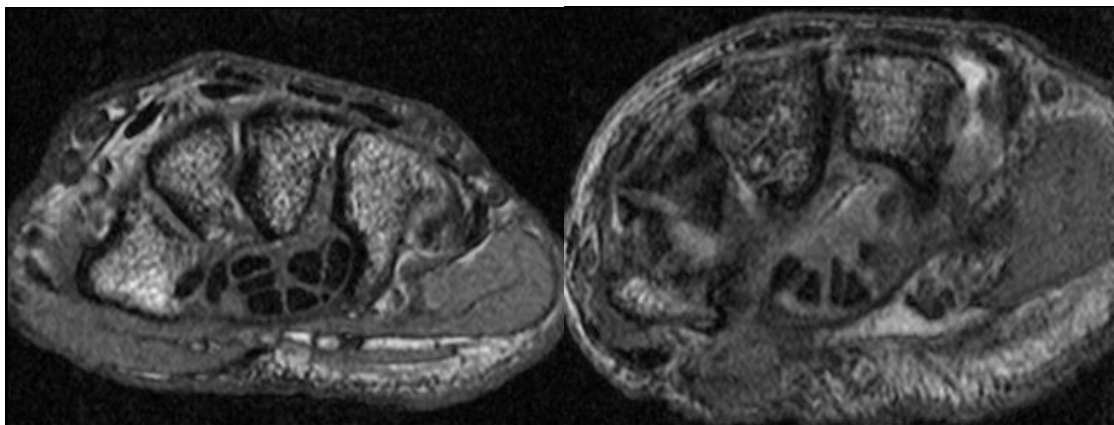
Two MR images within the carpal tunnel. The left image would be fast to segment because nearly all of the tendon boundaries are well defined. The image on the right is affected by the magic-angle effect in half of the tendons so this image would take longer to segment due to the necessary manual editing.
